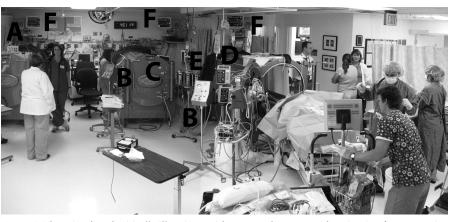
Three intubated critically ill patients with acute carbon monoxide poisoning from operating a propane-powered heater in a tent while hunting. The two patients on the left are compressed in chambers. Before compression in the chamber, the patient on the right needed placement of a central line and arterial catheter (in process) because echocardiography demonstrated global hypokinesis and inotropic support was needed. Magellan (controls are identical to the Omni-vent ventilator) (*A*) (21) and Sechrist 500A (*B*) (20) ventilator control modules are depicted. Each patient required several intravenous infusions perforating the chamber hatches (*C*). Baxter (*D*) (34) and IVAC (*E*) (33) intravenous infusion pumps and physiologic monitors (*F*) are depicted.
